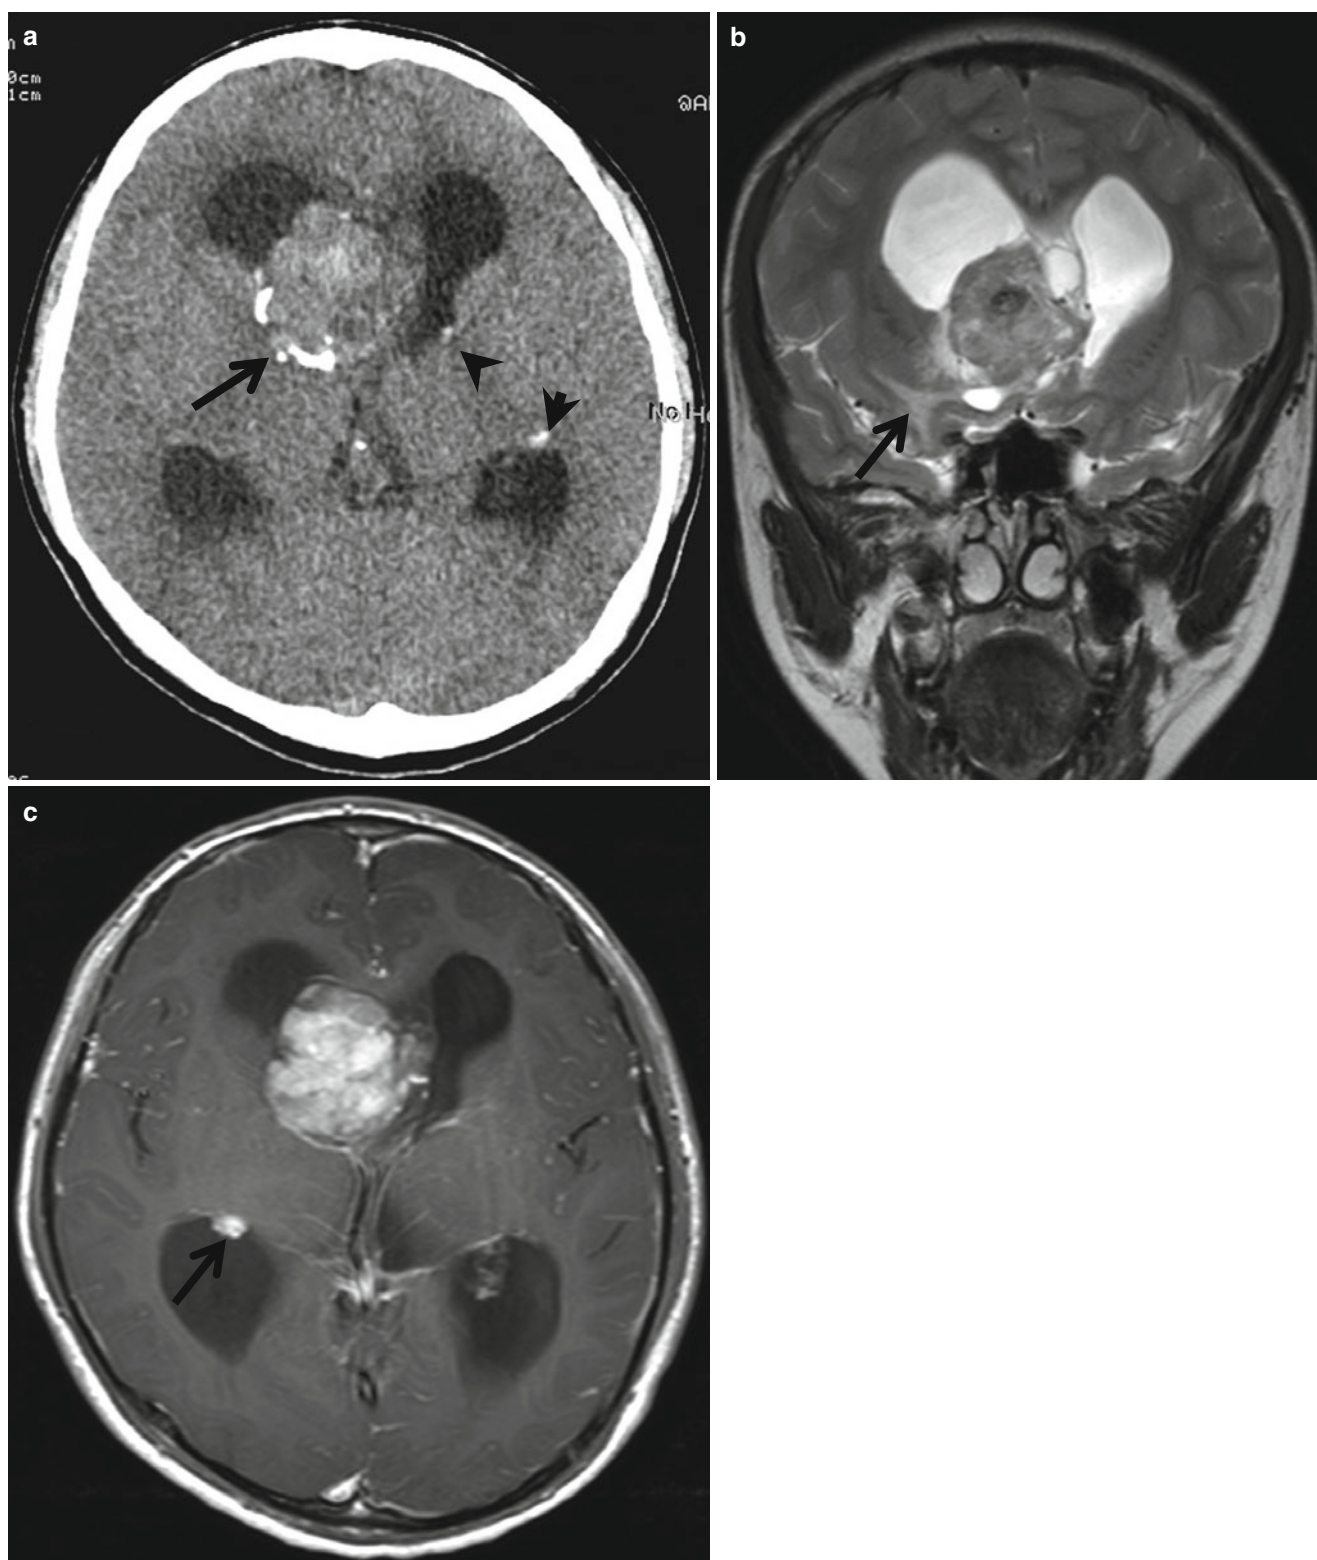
Giant cell astrocytoma in a patient with tuberous sclerosis. (a) Precontrast CT scan shows lobulating mass with calcification (arrow) at the right foramen of Monro resulting in ventricular distension. Multiple subependymal calcified nodules are noted (arrowheads), suggesting tuberous sclerosis. (b) The mass shows slightly high intensity, containing dark spots associated with mild peritumoral edema on a
